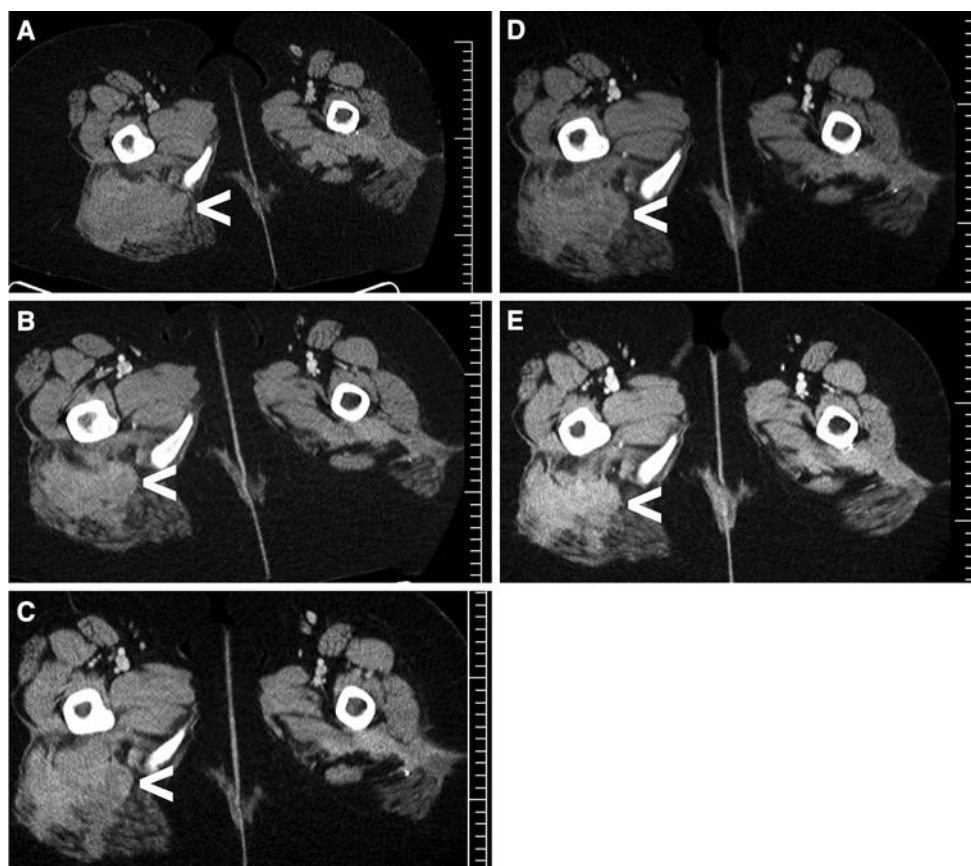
CT scans at the start of sunitinib (a), after 13 months of sunitinib (b), after 8 weeks of imatinib (c), after 1 month of sunitinib following imatinib cessation (month 16.5 after first starting sunitinib) (d), and 23.6 months after first starting sunitinib (e). The tumor is indicated by “<”
